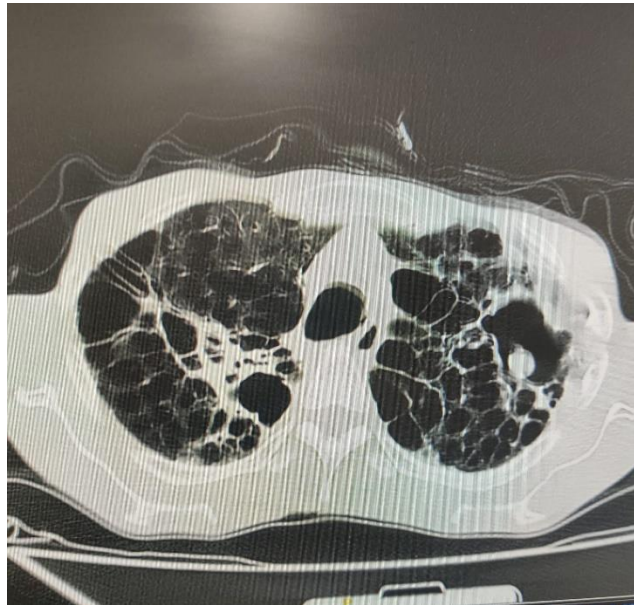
showing HRCT Thorax revealed Bronchiectatic changes in right upper lobe, few subpleural bullae noted in right upper lobe, cavity with internal soft tissue density area noted in anterior segment of left lower lobe
